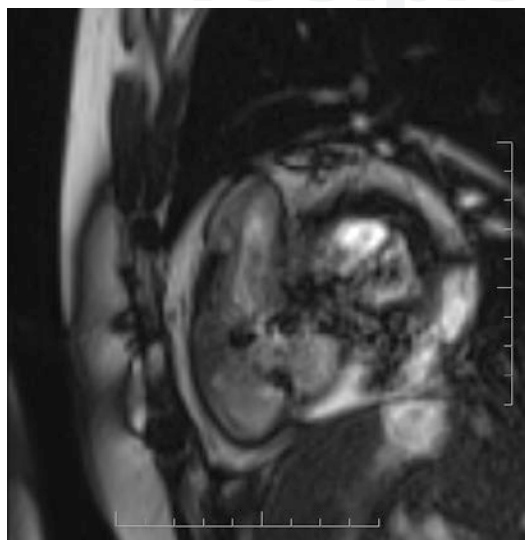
Cardiac magnetic resonance imaging demonstrating prosthetic tricuspid valve replacement in a patient with Ebstein anomaly
